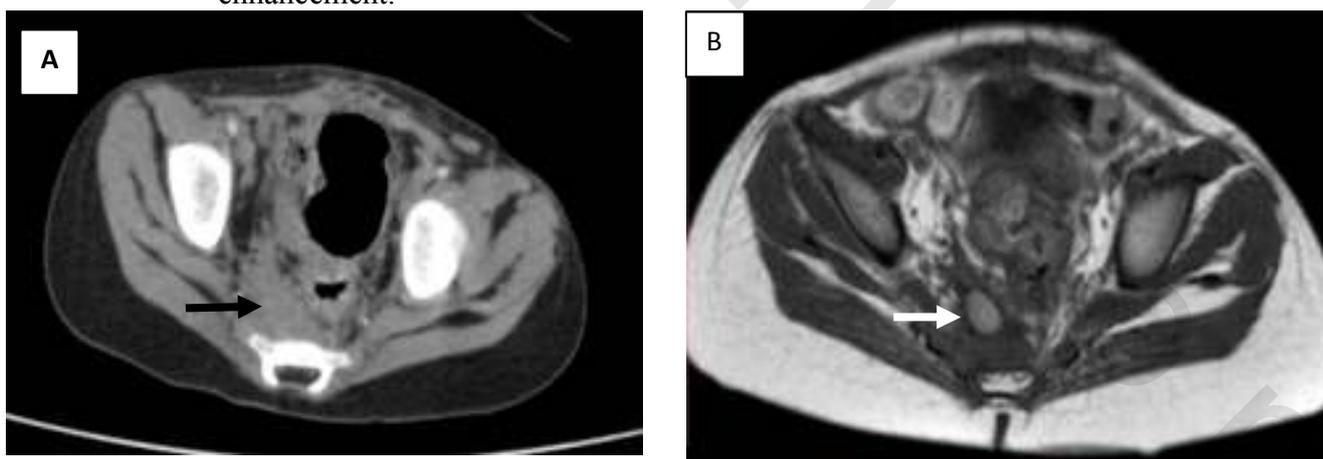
Case 12: (A) axial CT shows a small non enhancing presacral soft tissue lesion mildly displacing the rectum to the left side. (B) Axial T1 MRI showing a well defined hyper intense nodule in the centre of the hypointense presacral fibrotic lesion. This was diagnosed as a small recurrence.
